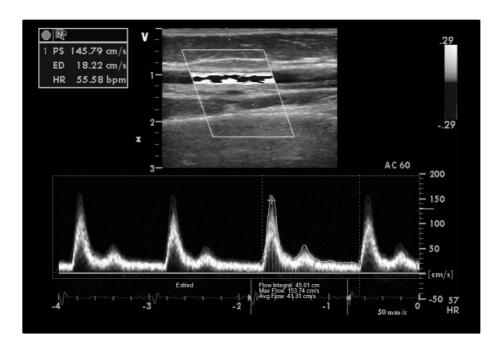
Example doppler ultrasound image of the brachial artery for the analysis of blood flow velocity and shear stress rates.
